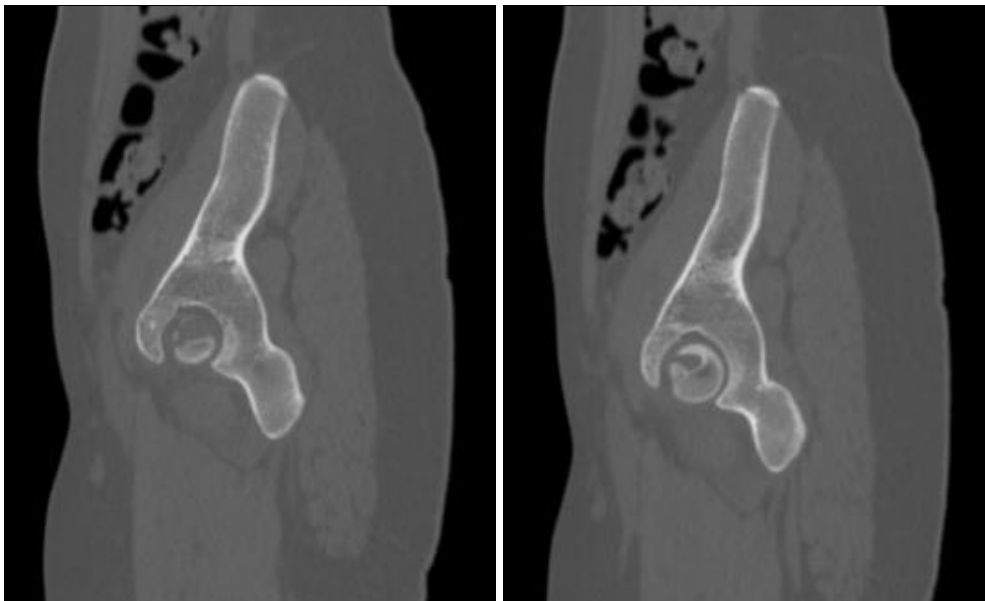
Coronal Pelvis CT scan showing a fragment of the avulsed femur head fracture at the level of Fovea Capitis in this cut.
